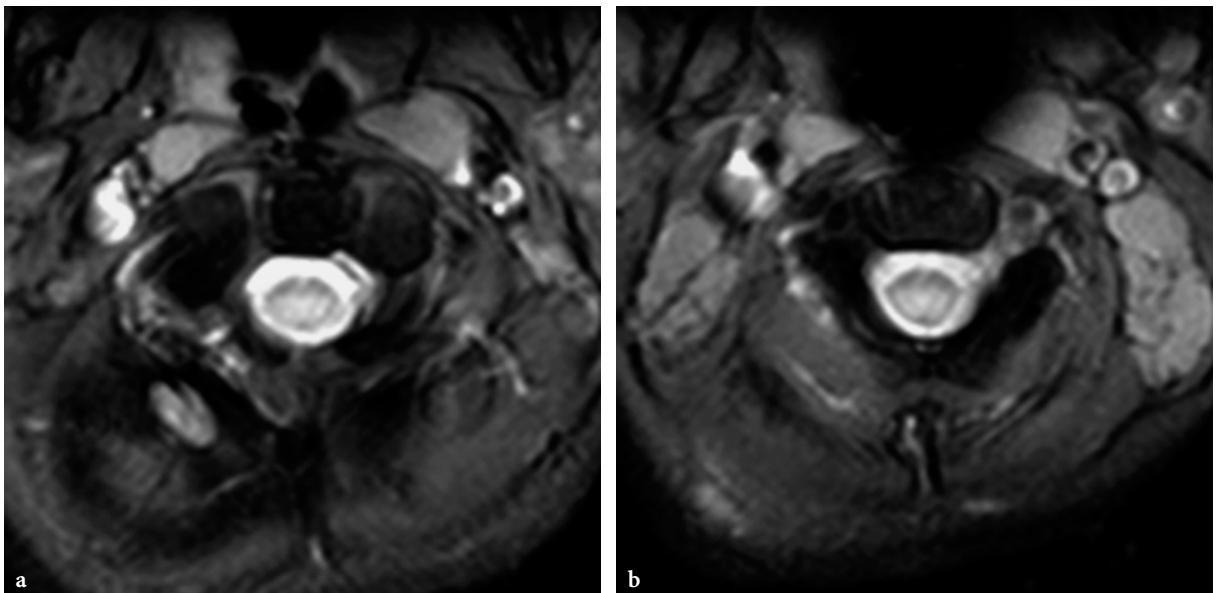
Spinal cord involvement in globoid cell leukodystrophy (Krabbe disease). a, b Axial T2-weighted gradient-echo images of the cervical spine (same patient as in Fig. 13.90), showing obvious signal abnormalities within the spinal cord
